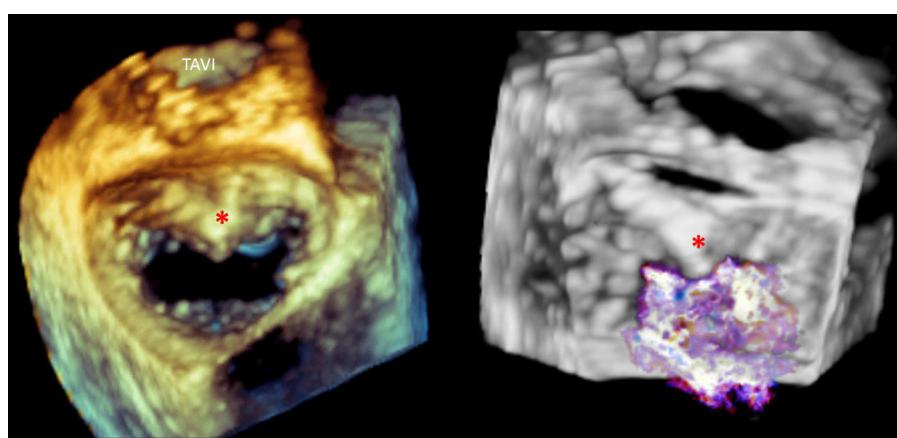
Three-dimensional transesophageal echocardiogram with a view of the mitral valve from the left atrium in patient 5. The asterisk indicates an area of calcification along the mitral-aortic curtain. The regurgitation originates mainly on either side of the calcified area. TAVI, transcatheter aortic valve implantation.
